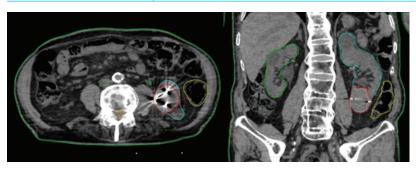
Left renal volume delineation from the treatment CT scan in the axial and coronal planes.
